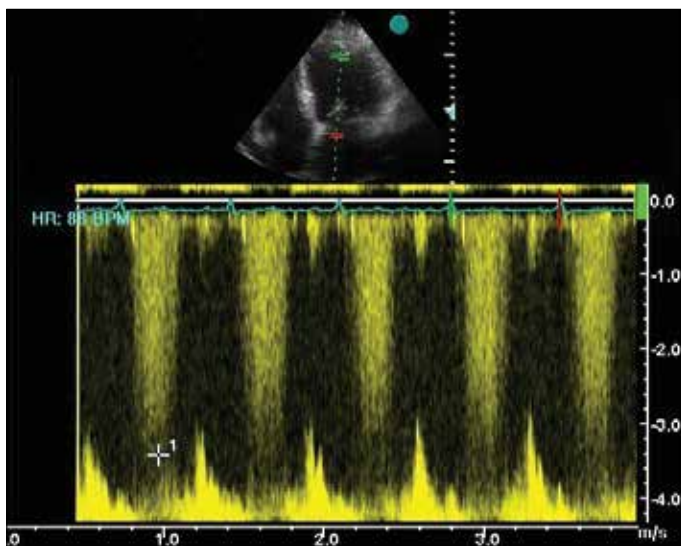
Pulsed-wave Doppler revealed the presence of ASF in a patient with severe MR. There is a holosystolic flow at the distal third of LV near the apex
